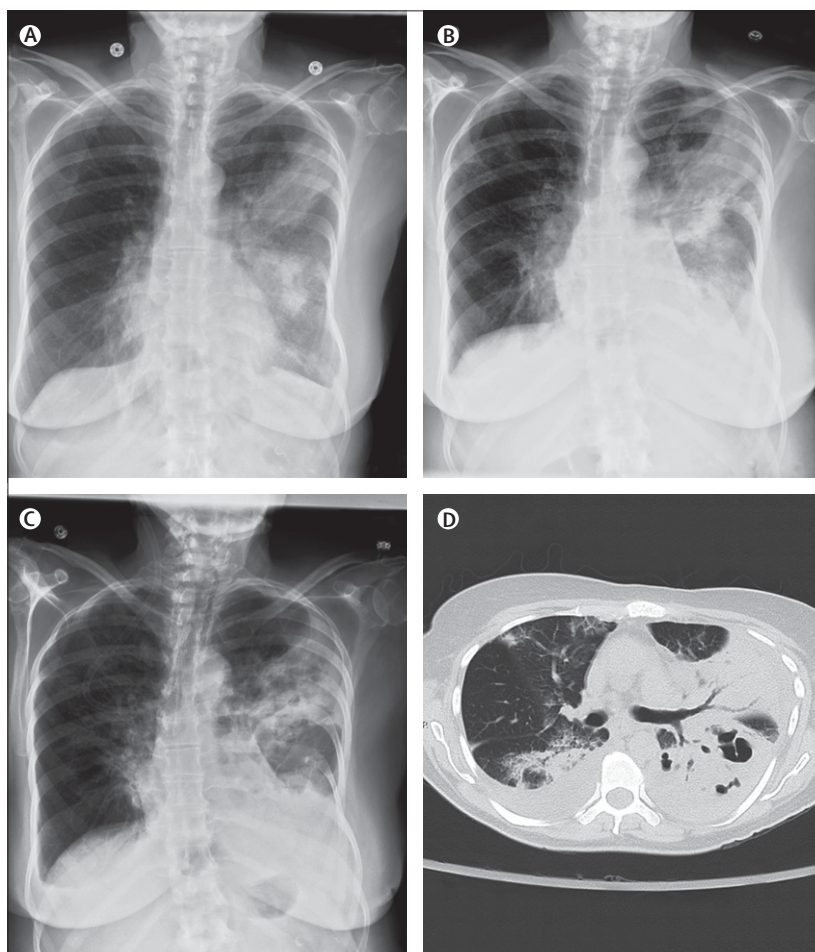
Typical radiographic findings in pneumococcal pneumonia
